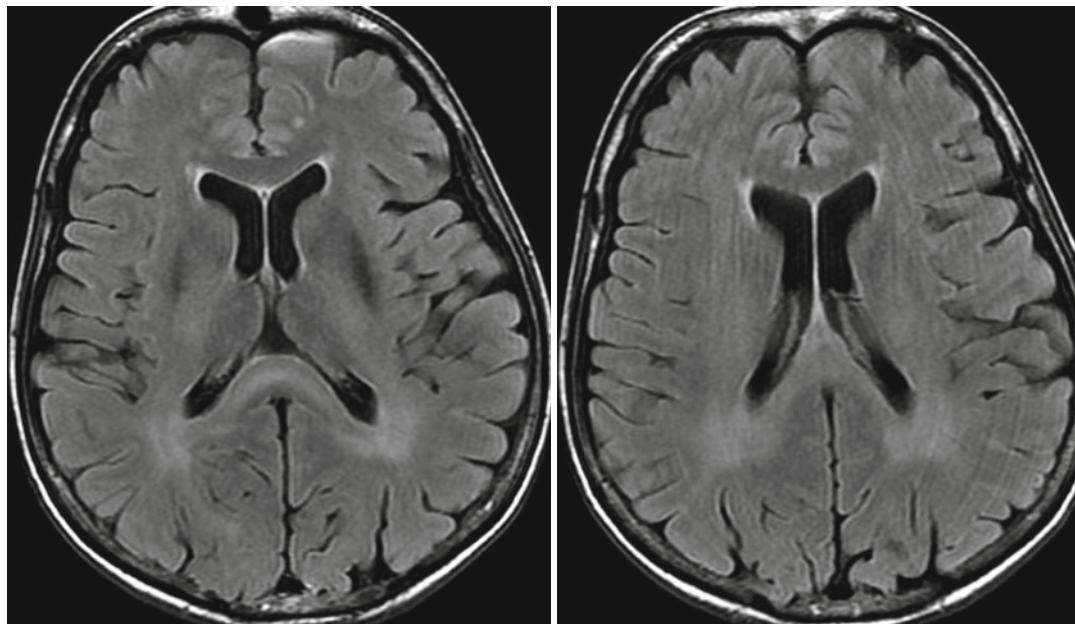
Leukopathy in a patient treated with 5-FU for ovarian cancer with peritoneal carcinosis. After the 3rd cycle of 5-FU, the patient became stuporous. MRI
